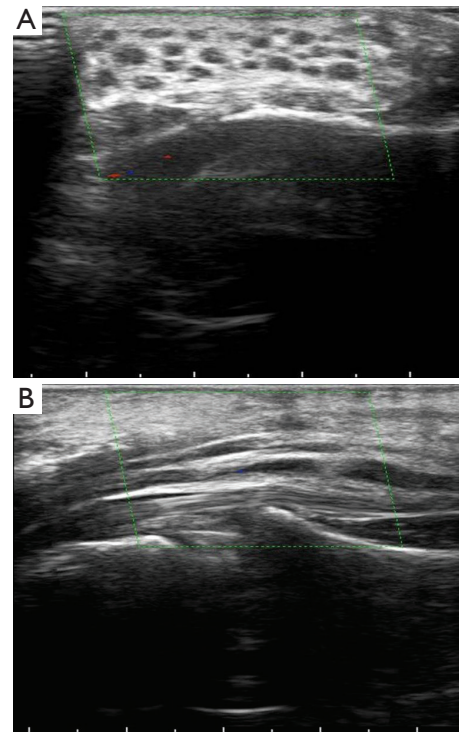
Axial (A) and longitudinal (B) images of ultrasound with color doppler show hypoechoic thickened axonal bundles interspersed in echogenic fatty tissue with no intralesional flow.
